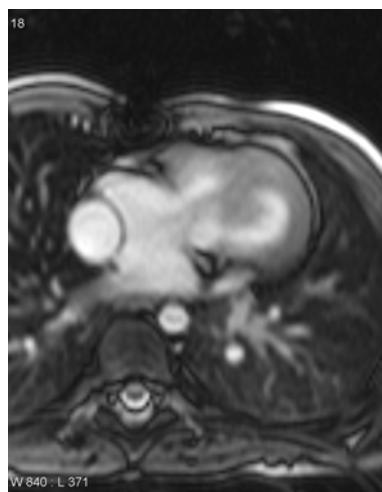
MRI of single ventricle anatomy with lateral tunnel Fontan modification. The ASD allowing communication of the atria is also shown.
